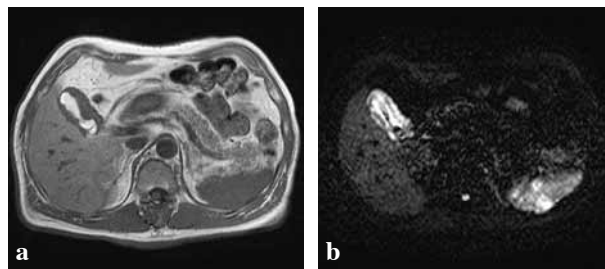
The gallbladder lesion showed low-intensity on T1-weighted magnetic resonance (MR) images (a) and high intensity on diffusion-weighted (DW) images (b).
